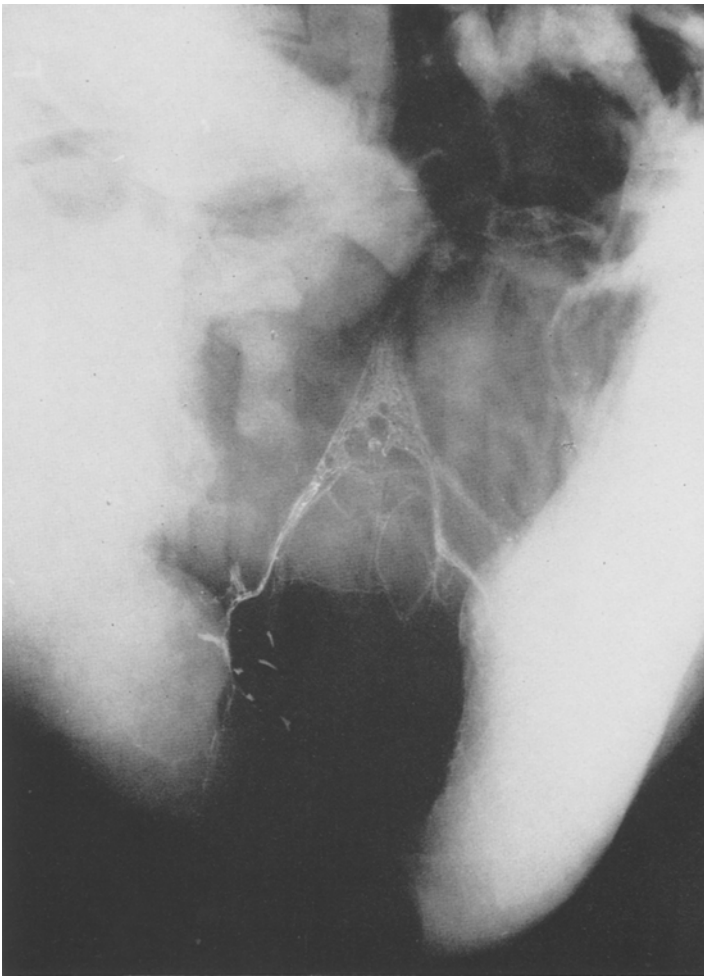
Radiologic visualisation of the left ventricular av-bundle on a calf heart. X-ray contrast medium is a tantalum suspension
